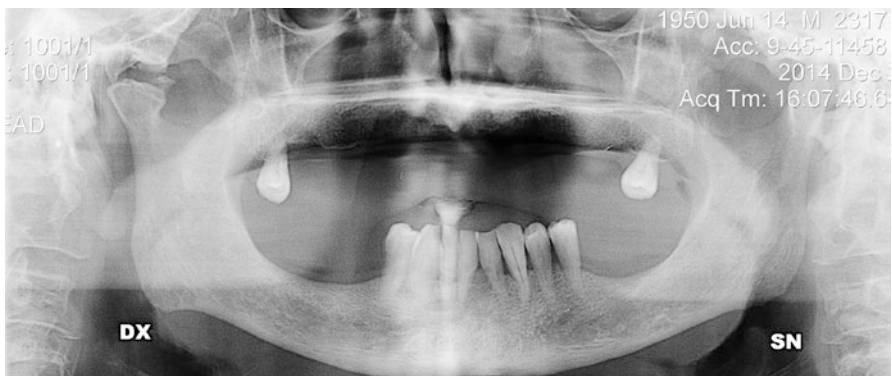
Severe osteoarthritis can be detected on orthopantomography
